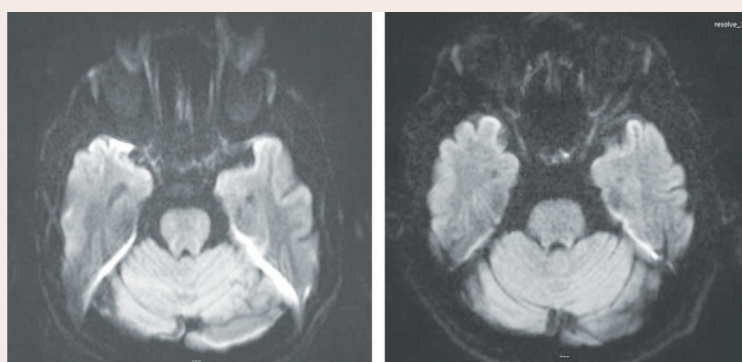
Comparison of SS-EPI (left) and RS-EPI DWI (right). At temporal lobe of RS-EPI, it shows not only less image distortion in phase direction (Antero-posterior), but also shows a reduction in hyper-intensity signal.
